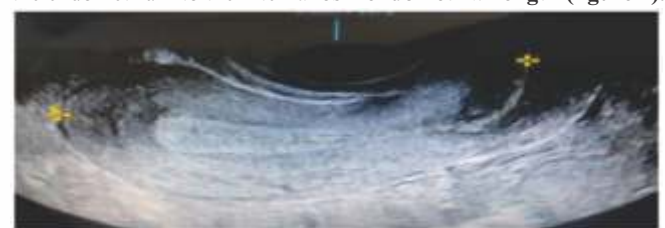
mid saggital plane of uterus on B mode ultrasound measuring endometrial length
